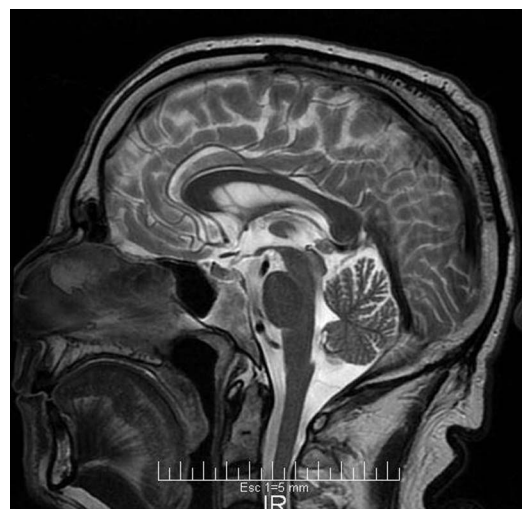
Sagittal T2-weighted image showing mild cerebellar atrophy.
